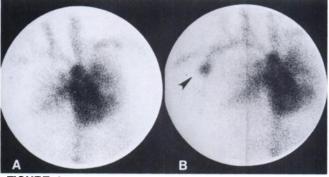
Anterior scintigram of chest after red-cell labeling with ⁹⁹mTc. (A) At 5 min postinjection, there is normal blood-pool activity. (B) At 60 min, there is abnormal collection of tracer in the right chest (arrow) at the site of bleeding.
